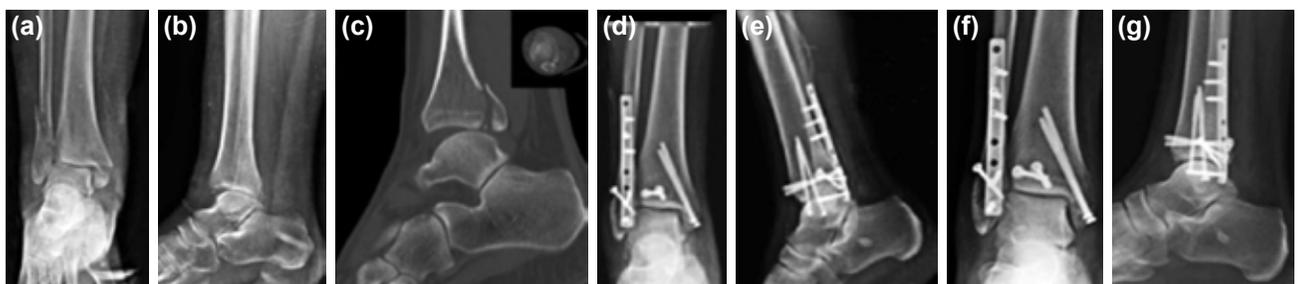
Posterior malleolus fracture treated with posteroanterior screw fixation (a) preoperative anteroposterior X-ray, (b) preoperative lateral X-ray, (c) preoperative sagittal section, (d) intraoperative anteroposterior X-ray, (e) intraoperative lateral X-ray, (f) postoperative 2-year X-ray, (g) postoperative 2-year lateral X-ray.
